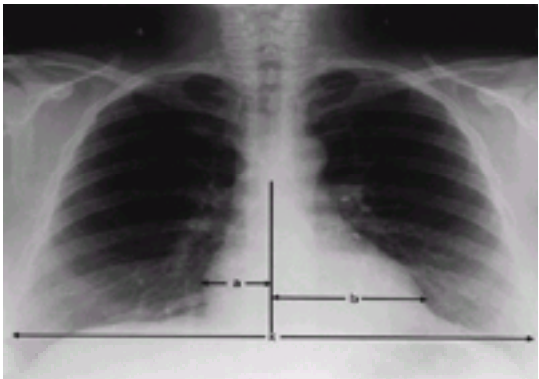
A normal posteroanterior chest radiograph showing how to calculate the cardiothoracic ratio (equal to $(a+b)/x$), which *should* normally be less than 0.5.
